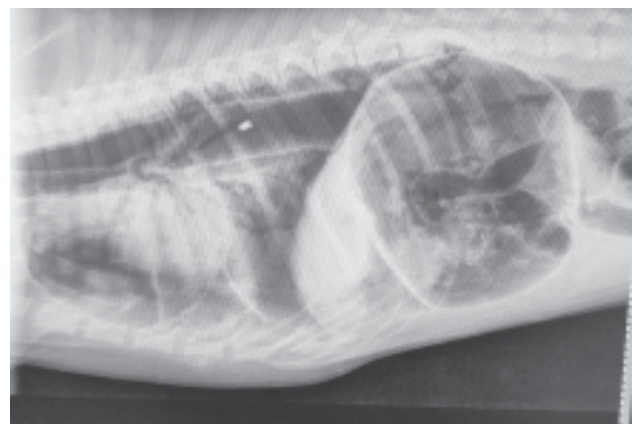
Lateral thoracic radiographic view after thoracotomy shows the caudal migration of the pellet during intra-thoracic manipulation. Also the fluid opacity has reduced and the radiolucent appearance of the thoracic cavity was regained partially. Air bronchogram corresponding to lung lobe collapse is also visible in the cardiac area.
